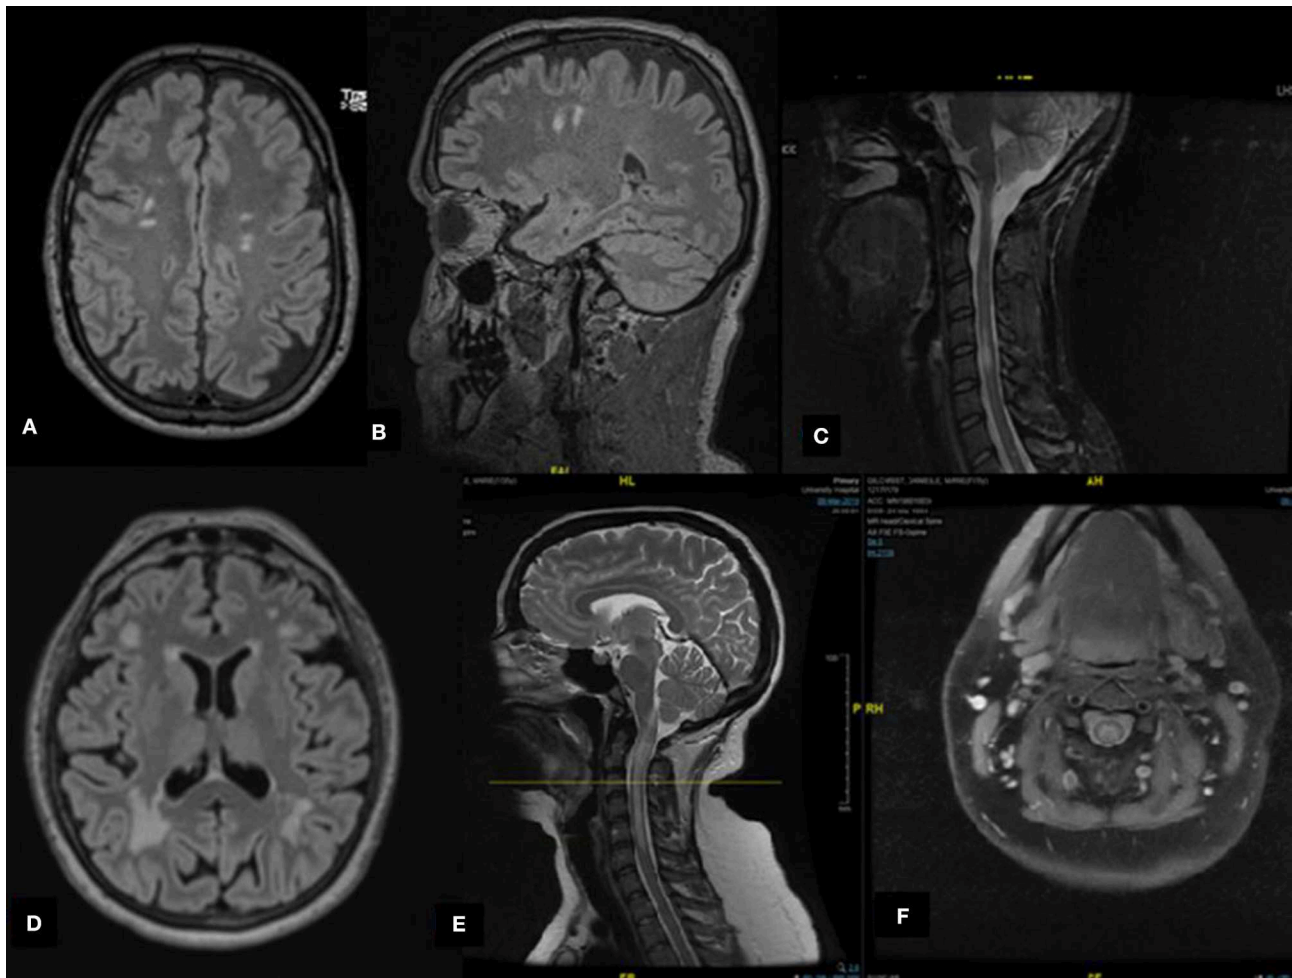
Radiological features of selected cases. (A,B) Case A: Axial and sagittal magnetic resonance imaging (MRI) fluid attenuated inversion recovery (FLAIR) revealing multiple subcortical hyperintense lesions. (C) Case C: Sagittal MRI short-T1 inversion recovery of the cervical spine demonstrates cervical hyperintensities. (D) Case G: Axial MRI FLAIR revealing multiple hyperintense lesions involving subcortical and periventricular areas, predominantly in the occipital regions. (E,F) Case I: Cervical spine MRI T2 reveals a hyperintense lesion extending from the posterior medulla (area postrema) to the area between C5 and C6 of the spinal cord forming an H sign.
